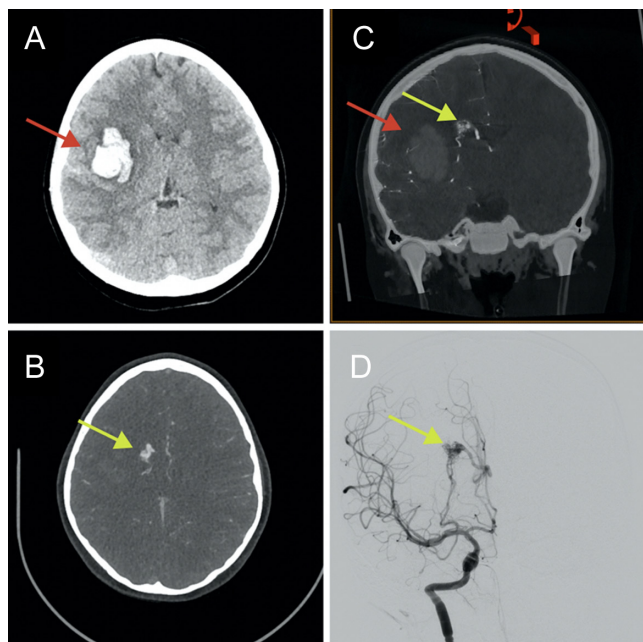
Imaging of the AVM at the time of initial presentation. A: Axial noncontrast head CT scan on admission demonstrating acute, right-sided intraparenchymal hemorrhage at the putamen (red arrow). B: Axial CTA showing a hyperdensity (yellow arrow) concerning for a vascular malformation. C: Coronal noncontrast CT scan merged with the angiogram demonstrating the hematoma (red arrow) as well as the AVM with lenticulostriate feeders and drainage via the caudate vein (yellow arrow). D: Right internal carotid artery (ICA) injection and anteroposterior view during initial angiography demonstrating a right AVM with deep drainage (yellow arrow).
